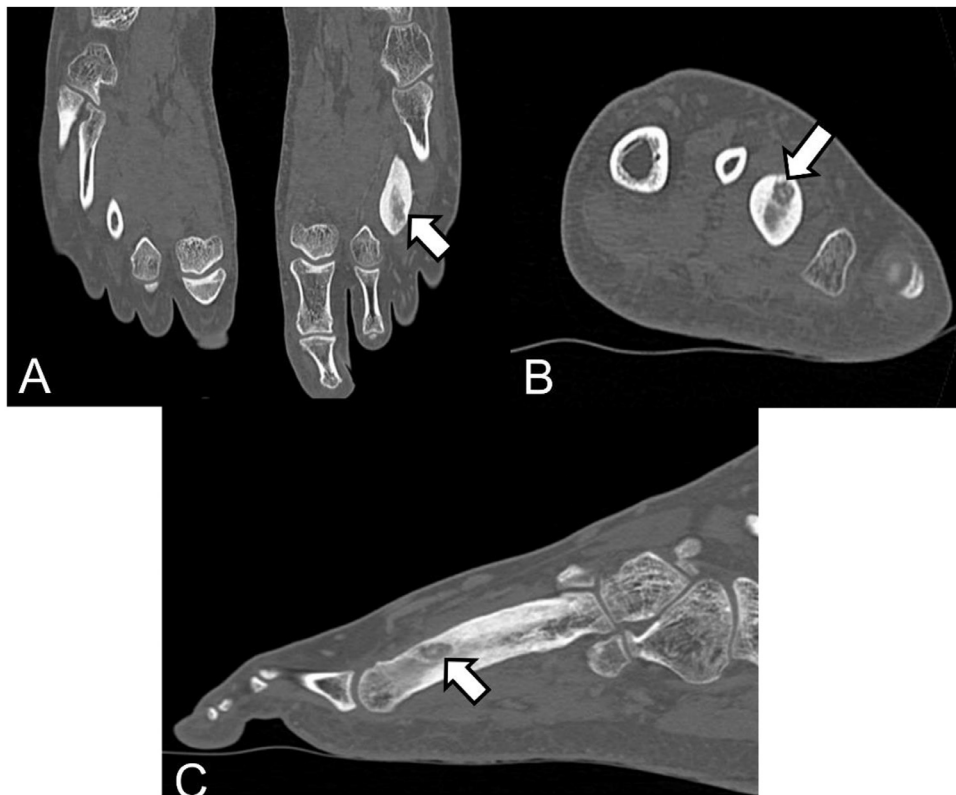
Preoperative CT scan of the feet with multiplanar reconstruction (MPR) displays osteoid osteoma (OO) as a hypodense nidus (arrow) with a central hyperdense spot (ovum) in the diaphyseal portion of third left metatarsal bone.
